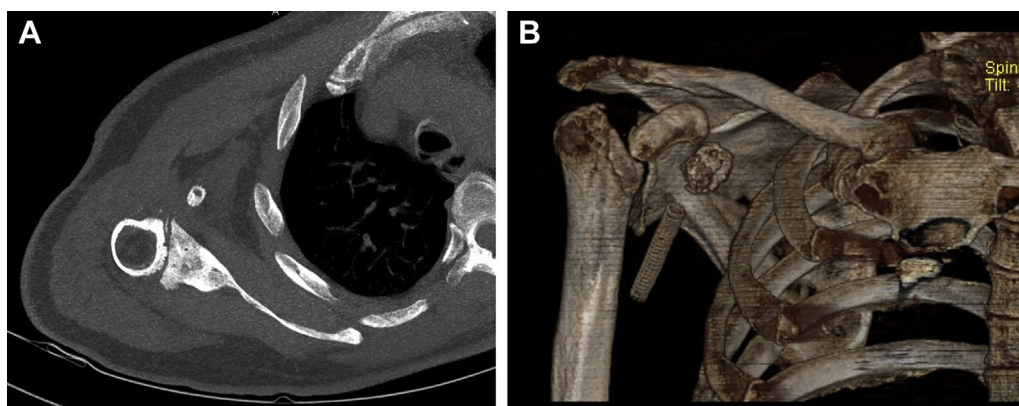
(A) Axial view of noncontrast CT of the right shoulder showing the proximity of the axillary artery stent to the glenohumeral joint. (B) Three-dimensional CT image of the right shoulder showing the humeral cut and axillary artery stent. *CT*, computed tomography.
